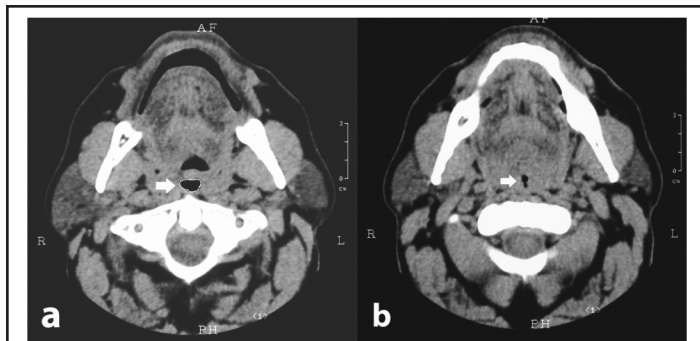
Preoperative computed tomographic scan of the minimal retropalatal area. (a) tidal breathing. (b) Muller maneuver. Arrows point to the retropalatal airway.
